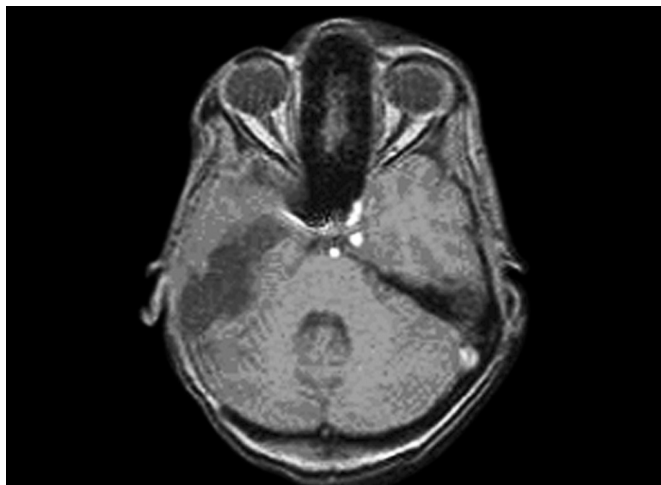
Magnetic resonance imaging (MRI) of the brain and internal auditory canals revealing a right skull base chondrosarcoma measuring at least 5 cm with a small area of extra-axial extension into the right posterior fossa over the cerebellar hemisphere.
